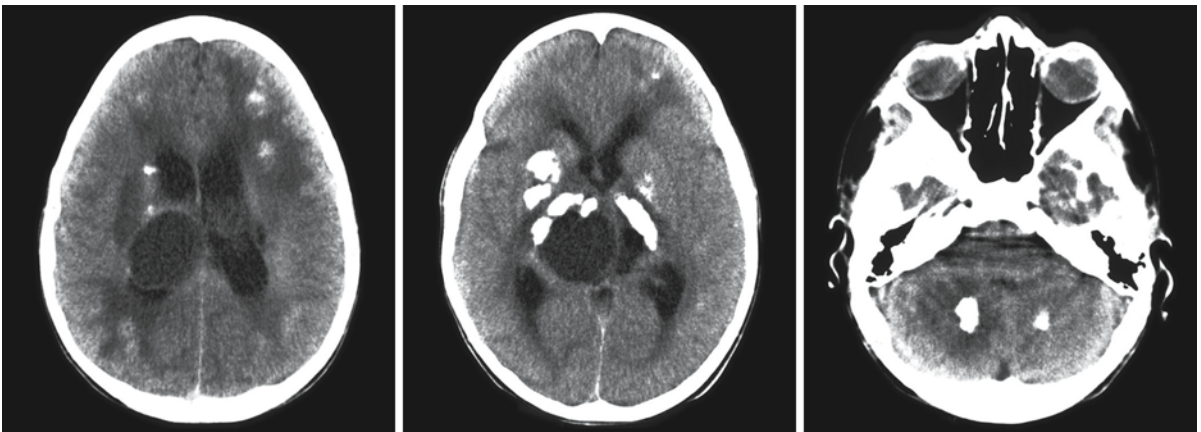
The same patient, now 13 years old. There is a growing cyst in the region of the thalamus on the right. The CT scan shows the calcium in the basal ganglia, thalami, and dentate nuclei. There are multiple calcium deposits in the cortico-subcortical junction in the cerebral hemispheres
